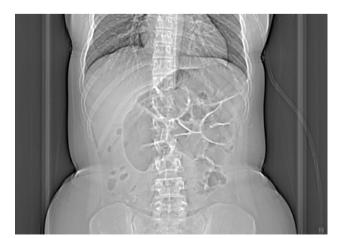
Wide-base small intestine type air-fluid levels on standing direct abdominal radiography.
